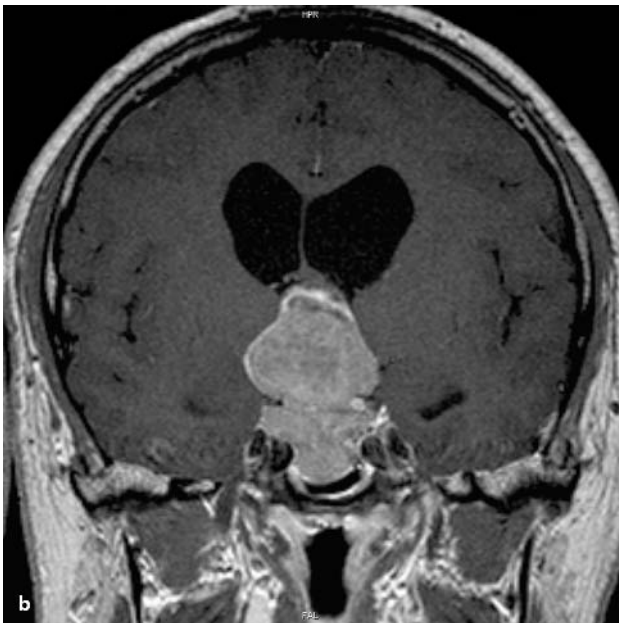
Intra- and suprasellar pituitary macroadenoma with typical lobulated figure-of-eight or “snow man” appearance in sagittal (a) and coronal (b) contrast-enhanced T₁-weighted MR images
